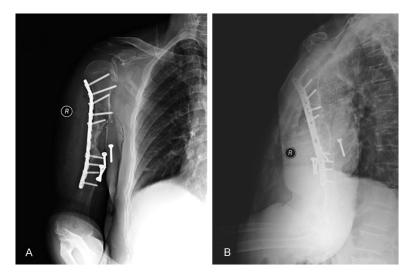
Anteroposterior (A) and lateral (B) radiographs after ORIF and bone grafting.
